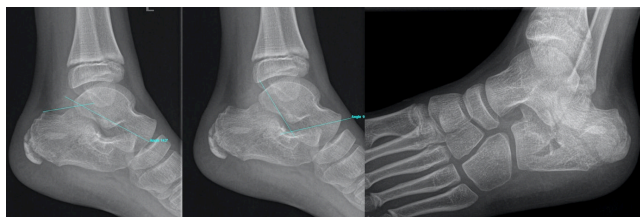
Simple radiograph showing the intra-articular fracture of the calcaneus with Böhler angle of 40° and Gissane angle of 109°, type 5B of the classification of pediatric calcaneal fractures (compression fracture of the subtalar joint with joint depression).
